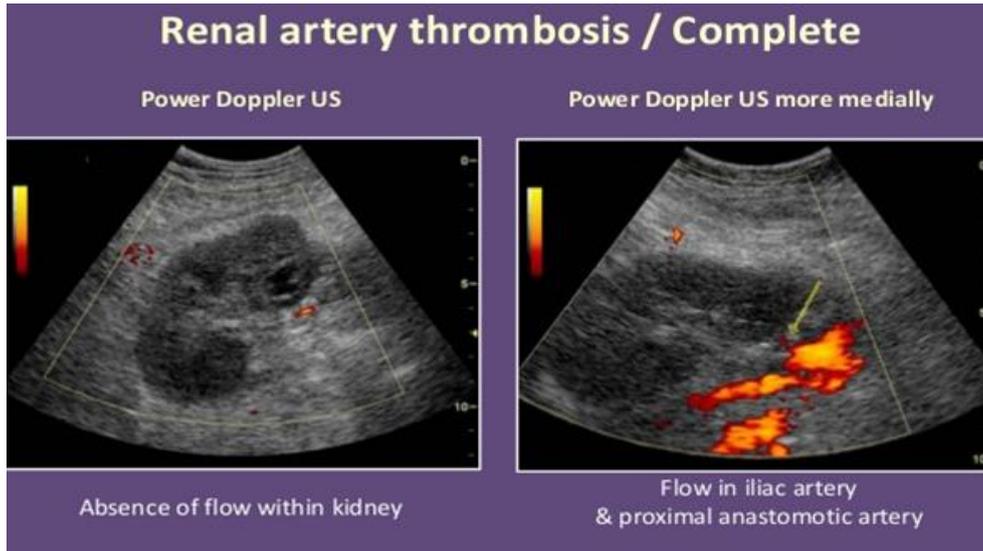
Color Doppler ultrasound showing renal artery thrombosis that is absence of blood flow to the kidney.⁽¹⁸⁾
